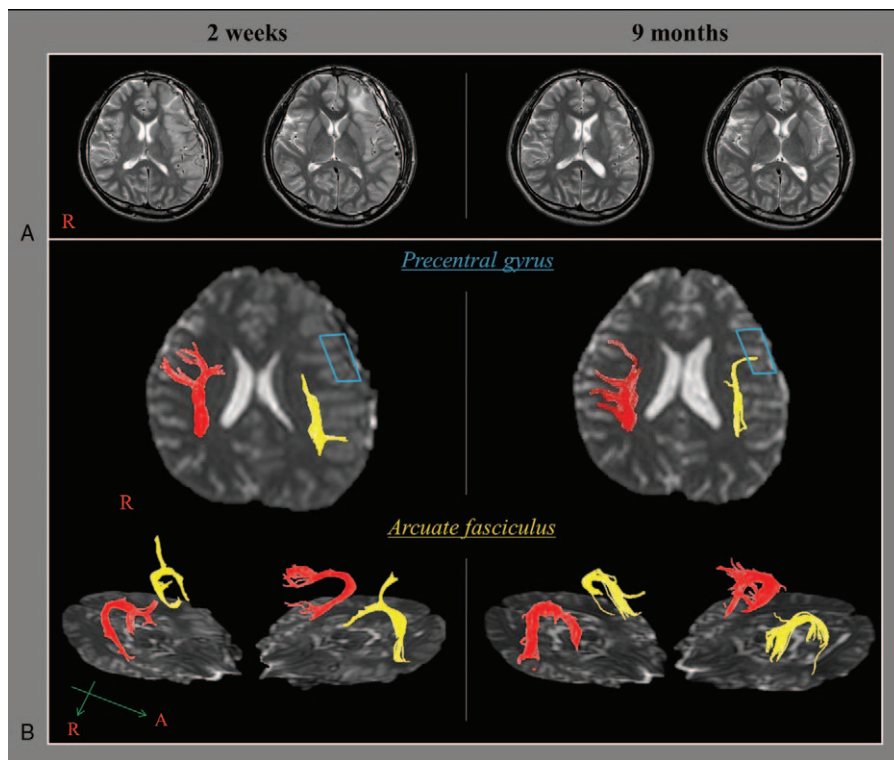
(A) Brain MR images at 2 weeks after injury show leukomalactic lesion in the left frontal lobe. (B) Diffusion tensor tractography for the arcuate fasciculus (AF, right AF: red color, left AF: yellow color). On 2-week DTT, the branch to Broca's area (sky-blue lined box) of the left AF is discontinued at the subcortical white matter (green arrow). By contrast, on 9-month DTT, the discontinued portion of the left AF is elongated to the left Broca's area (sky-blue lined box). AF=arcuate fasciculus, DTT=diffusion tensor tractography, MR=magnetic resonance.
